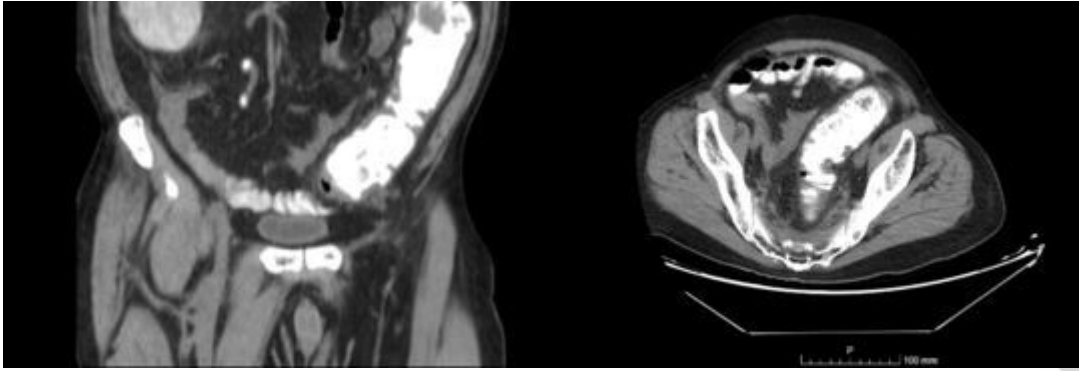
Abdominal CT scan with thickening of the walls of the descending colon compatible with colitis.
